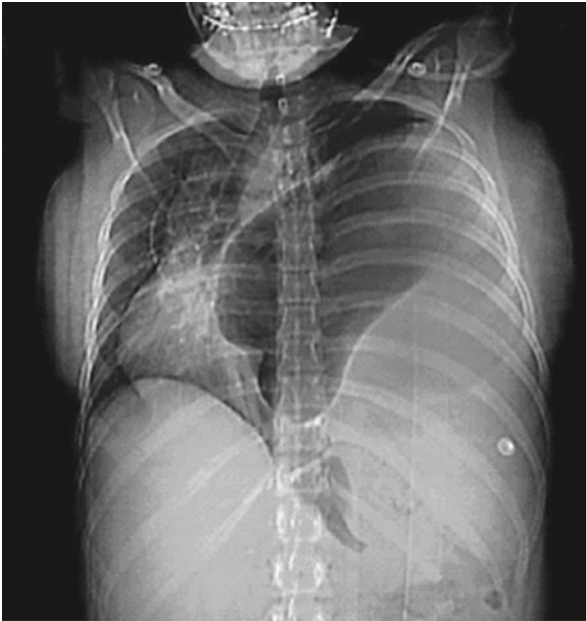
Scout film of the CT scan showing a distended stomach occupying the left hemithorax with gross shift of mediastinum to the right
